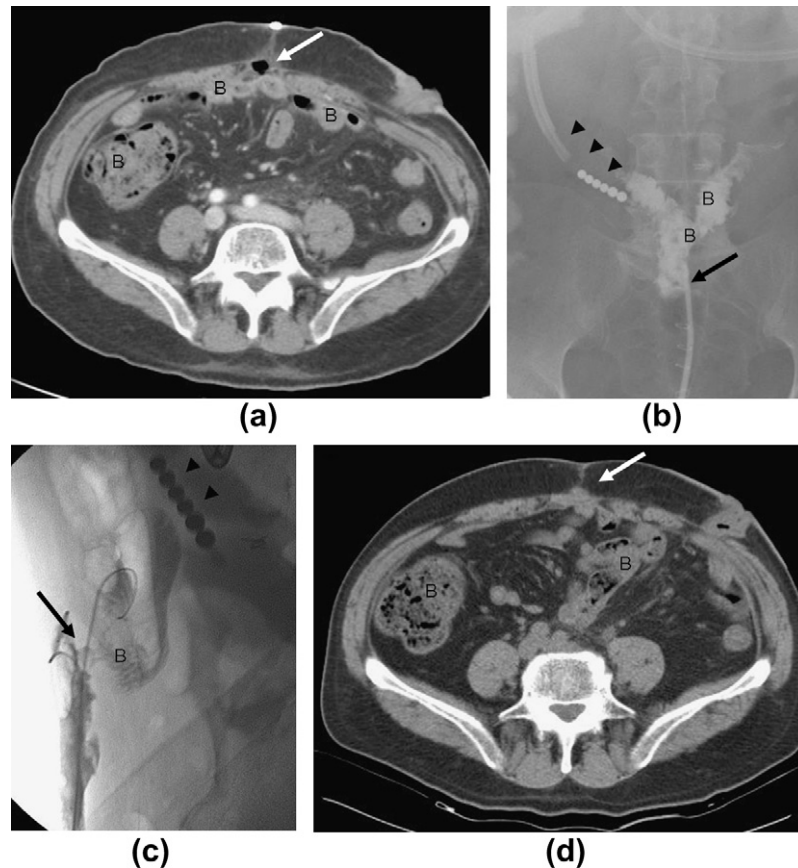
Treatment of an enteric fistula in a patient who underwent Miles' resection for rectal cancer. (a) A CT examination 11 days after surgery demonstrated an air–fluid collection (arrow) at the level of the surgical wound. B, bowel. (b) Contrast medium injection in the abdominal wound through a Fogarty catheter (arrow) demonstrated a direct connection with the bowel (B). Arrowheads indicate the naso-jejunal tube. (c) Glubran2 and Spongostan were injected through the percutaneous drainage catheter close to the site of the fistula (arrow). B, bowel; arrowheads indicate the naso-jejunal tube. (d) A CT examination at 10 months demonstrated the complete resolution of the fistula (arrow). B, bowel.
